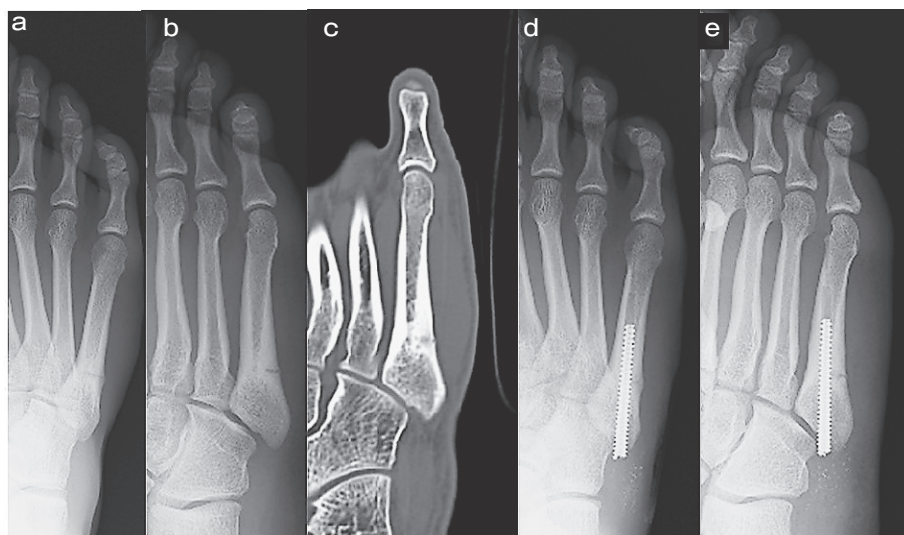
(Case 4) A-P (a) and oblique (b) preoperative foot X-ray and CT images (c), The Jones fracture of the right foot is visible; A-P (d) and oblique (e) X-ray images of the foot, Intramedullary screw fixation was performed with an Acutrak 4/5 screw at 1 month after injury. Circumstances necessitated the excision of the protruding proximal end of the screw.
